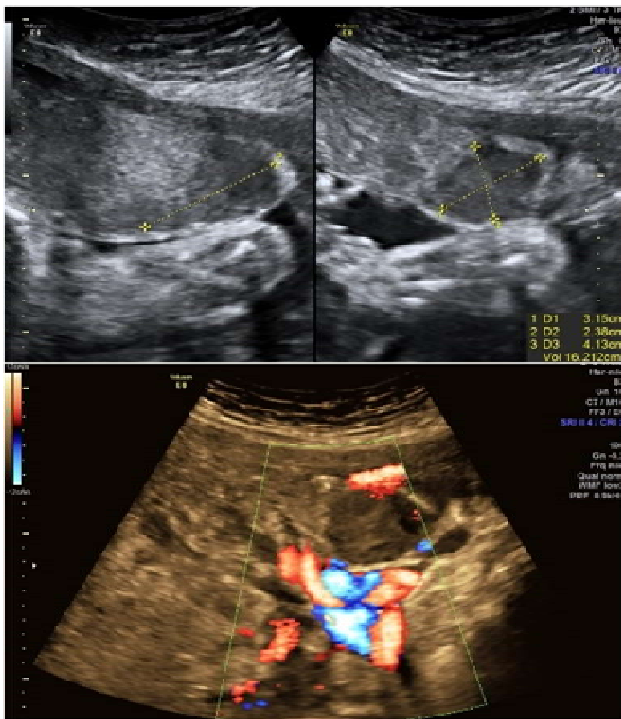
Vascular lakes and lacunae as seen on ultrasound and color doppler images
